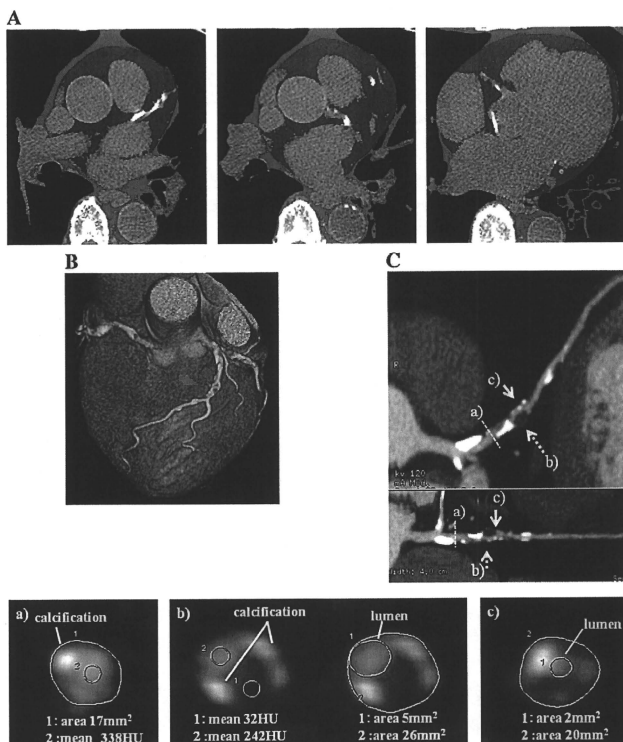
A representative case with high accumulation of EAT presenting coronary atherosclerotic plaque with vulnerable plaque components. A density range between -250 and -30 HU was assigned as the adipose tissue. The EAT area (blue area) was manually traced on the epicardium (panel A). In this case, the EAT volume was 216 ml. The volume rendering image shows an atherosclerotic lesion in the middle portion of the left anterior descending artery (LAD) (panel B, blue arrow). The multi-planar reconstruction image of LAD shows an obstructive non-calcified plaque lesion with low-density plaque, positive vascular remodeling, and adjacent spotty calcium (panel C). The remodeling index is 1.53 , calculated from the cross-sectional images of the reference site (a) and the lesion site (b). The minimum CT density of the lesion site is 32 HU. Adjacent spotty calcium can be observed in the cross-sectional image (a, b, and c).
